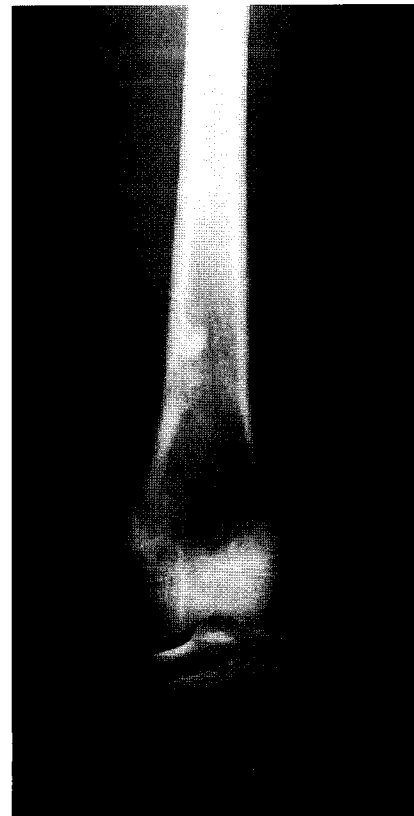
Radiograph showing abnormal sclerotic change and periosteal reaction at the distal end of the femoral shaft upon the initial presentation.
